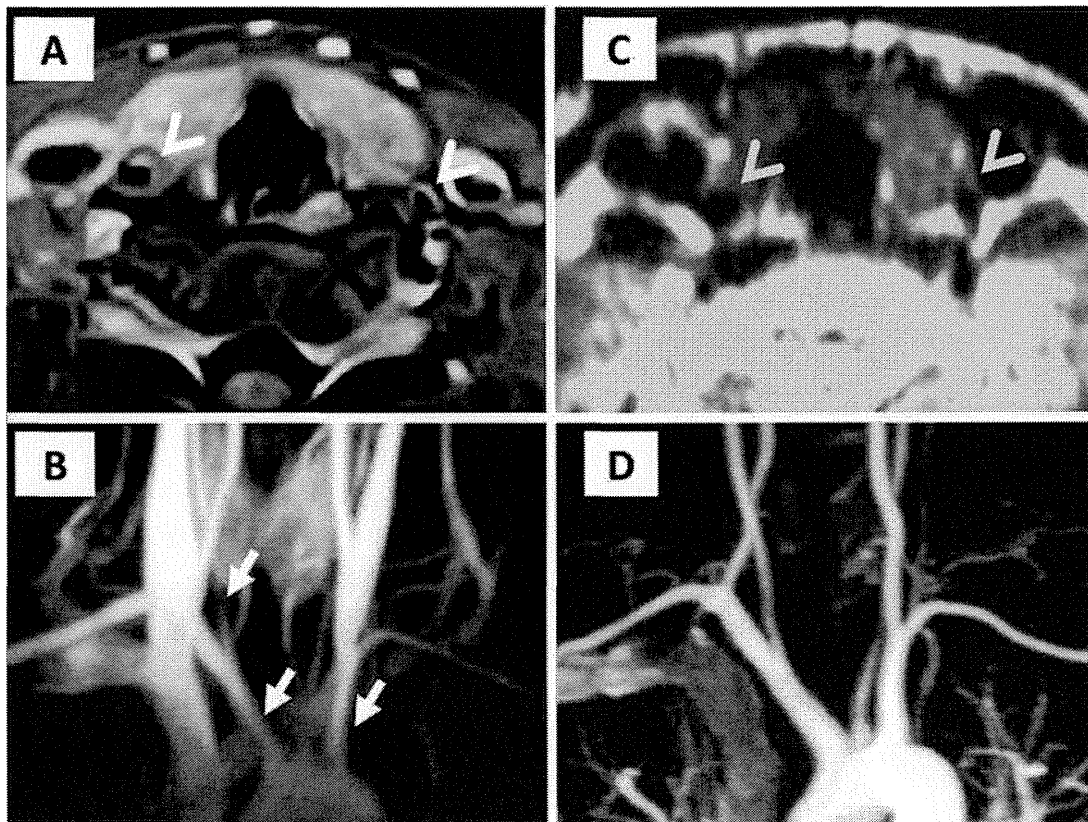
Neck and chest MRI findings. The left common carotid artery of this patient branches from the left brachiocephalic artery. A. T1-weighted image shows wall thickening of the left common carotid artery and right brachiocephalic artery (arrowheads). B. Magnetic resonance angiography shows stenosis of the right common carotid artery and bilateral brachiocephalic arteries (arrows) at diagnosis in August 2007. C. Magnetic resonance imaging in February 2011 during treatment with tacrolimus and subsequent sustained clinical remission shows normal vascular wall and (D) absence of new stenosis of arteries.
